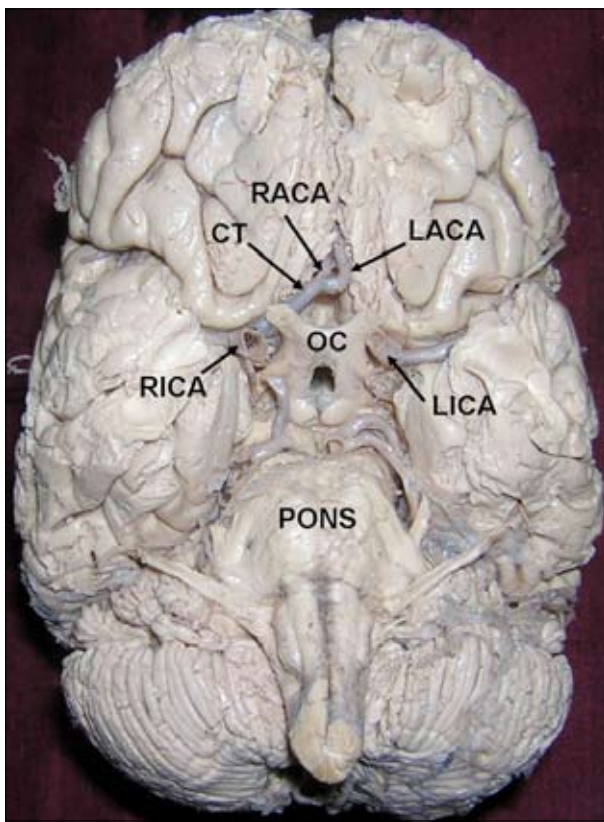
Photograph of the base of the brain showing anomalous arteries. Color version of figure is available online. (*RACA*: right anterior cerebral artery; *CT*: common trunk giving rise to right and left anterior cerebral arteries; *LACA*: left anterior cerebral artery; *RICA*: right internal carotid artery; *LICA*: left internal carotid artery; *OC*: optic chiasma)
